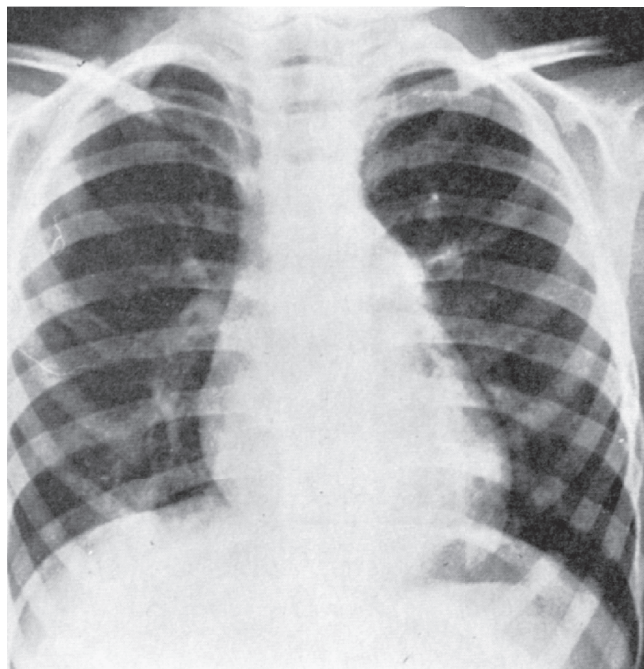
■ In contrast to the heart shown in Figure 117-5, the heart in this chest radiograph is not enlarged overall. The main pulmonary artery is enlarged, but there is no evidence of increased pulmonary blood flow. This patient has a large ventricular septal defect, pulmonary hypertension, severe elevation of pulmonary vascular resistance, and pulmonary blood flow that is less than systemic blood flow. The condition is inoperable and usually requires a heart-lung transplant or a lung transplantation with concomitant intracardiac repair. (Modified from Dushane JW, Kirklin JW: Selection for surgery of patients with ventricular septal defects and pulmonary hypertension. *Circulation* 21:13, 1960; with permission of the American Heart Association, Inc.)
